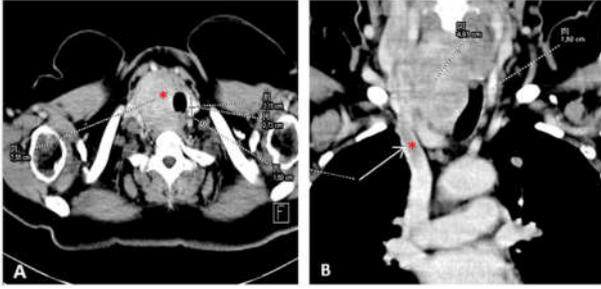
CT scan showing multinodular and heterogeneous aspect of the right thyroid lobe measured 7.55 cm(A),(asterisks)and thrombosis of the internal jugular vein (B),(asterisks).
